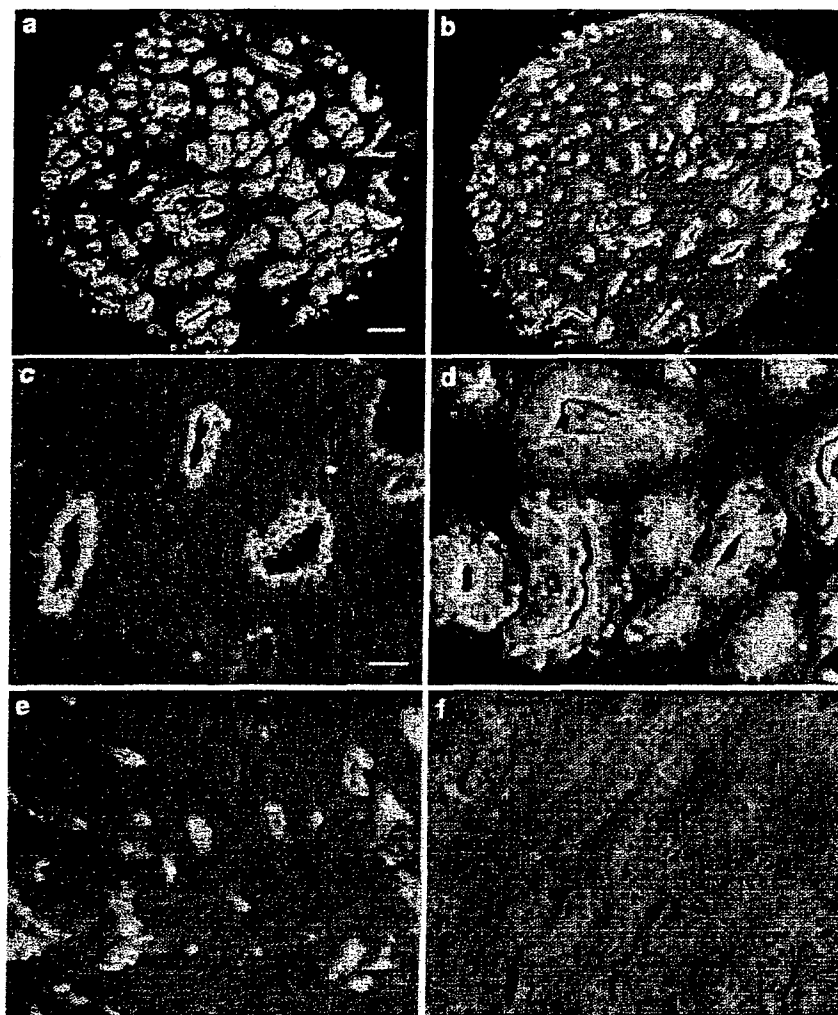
Tissue and subcellular distribution of MUC1 epitopes recognized by antibodies 214D4 and CT-1. Serial sections of Gleason grade 3 (a and b) probed with antibodies 214D4 (panel a) or CT-1 (panel b) displayed a similar tissue distribution. Subcellular distribution of MUC1 recognized by 214D4 ranged from apical only (panel c, Gleason grade 3), apical and diffuse cytoplasmic (panels d and e, Gleason grades 3 and 4, respectively), to diffuse cytoplasmic-low intensity (panel f, Gleason grade 4). Magnification bar for panels a and b located in panel a is 100 μ m, magnification for panels c-f located in panel c is 25 μ m.
